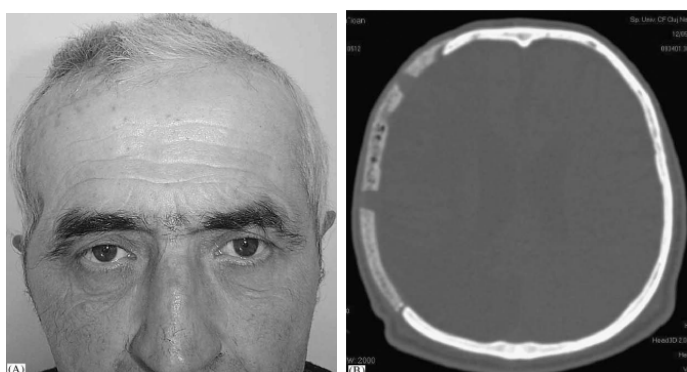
Postoperative aspect revealing the restored symmetry and (B) postoperative CT, note the perfect marginal adaptation of the reconstruction plate
